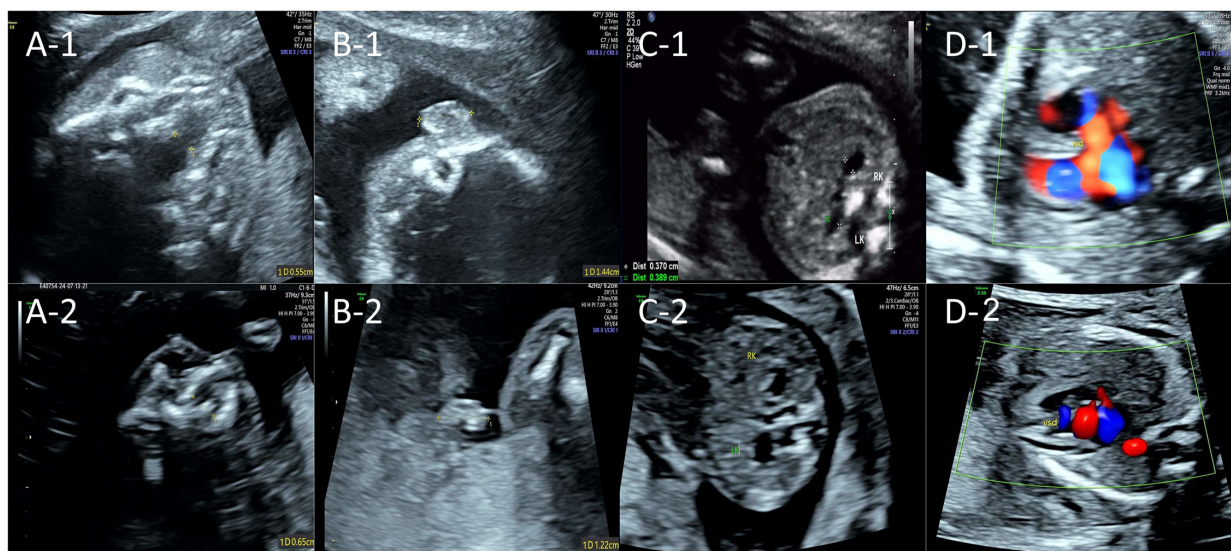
Fetal non-neurological ultrasound findings of two consecutive pregnancies. The upper row shows the prenatal ultrasound from the first pregnancy at 22⁺4 weeks of gestation; the lower row shows that from the second pregnancy at 17⁺4 weeks of gestation. (A-1,2) Ultrasound suggested a cleft palate; (B-1,2) Ultrasound suggested unilateral (right) microtia; (C-1,2) Ultrasound suggested mild bilateral renal pyelectasis; (D-1,2) Ultrasound suggested a ventricular septal defect.
